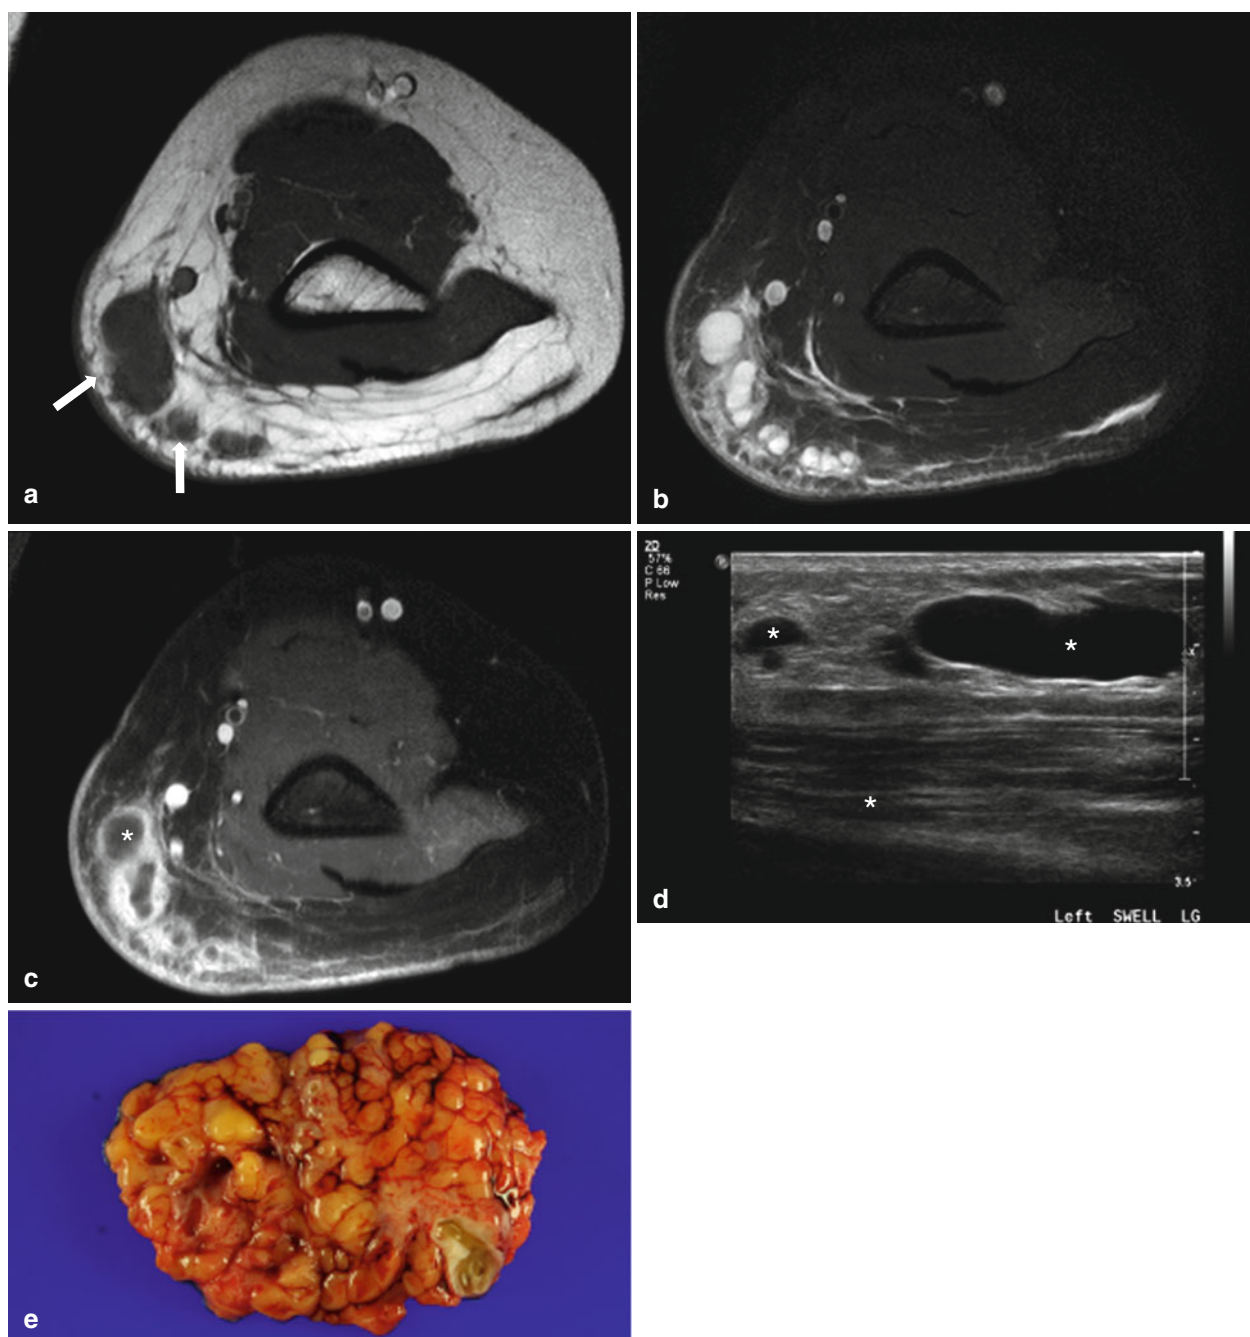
MR images and gross photograph of a 13-year-old boy with lymphatic malformation at the left upper arm. (a) Axial T1-weighted MR image shows multiloculated subcutaneous mass (*arrows*) that is predominantly isointense relative to muscle, with some hyperintense subcutaneous fat interspersed within the lesion. (b) Axial fat-suppressed T2-weighted MR image shows the mass with multilocular cystic portions that show fluid signal. (c) Axial gadolinium-enhanced
